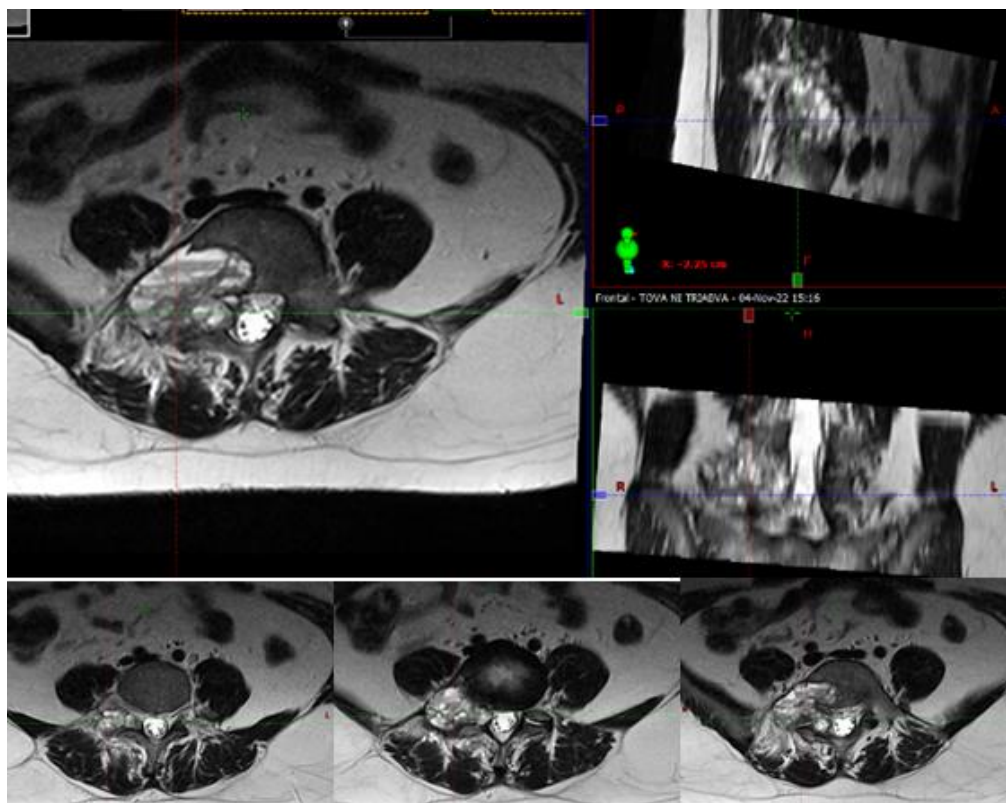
MRI of the spine/November 2022; Tumor process on the right, involving the body and right pedicle of the fifth lumbar vertebra (L5), exerting anterolateral compression on the dural sac and nerve root at this level
